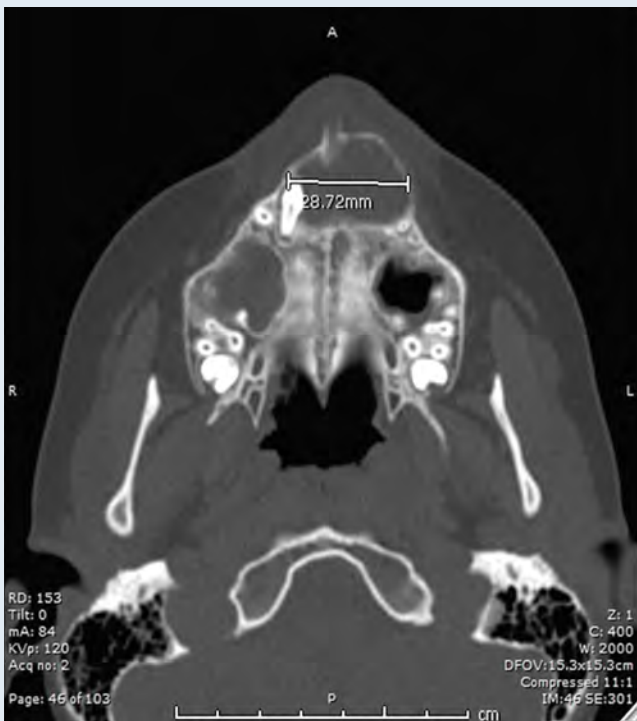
Axial section of CT image showing well-circumscribed radiolucency associated with impacted tooth #6 in anterior maxilla.
